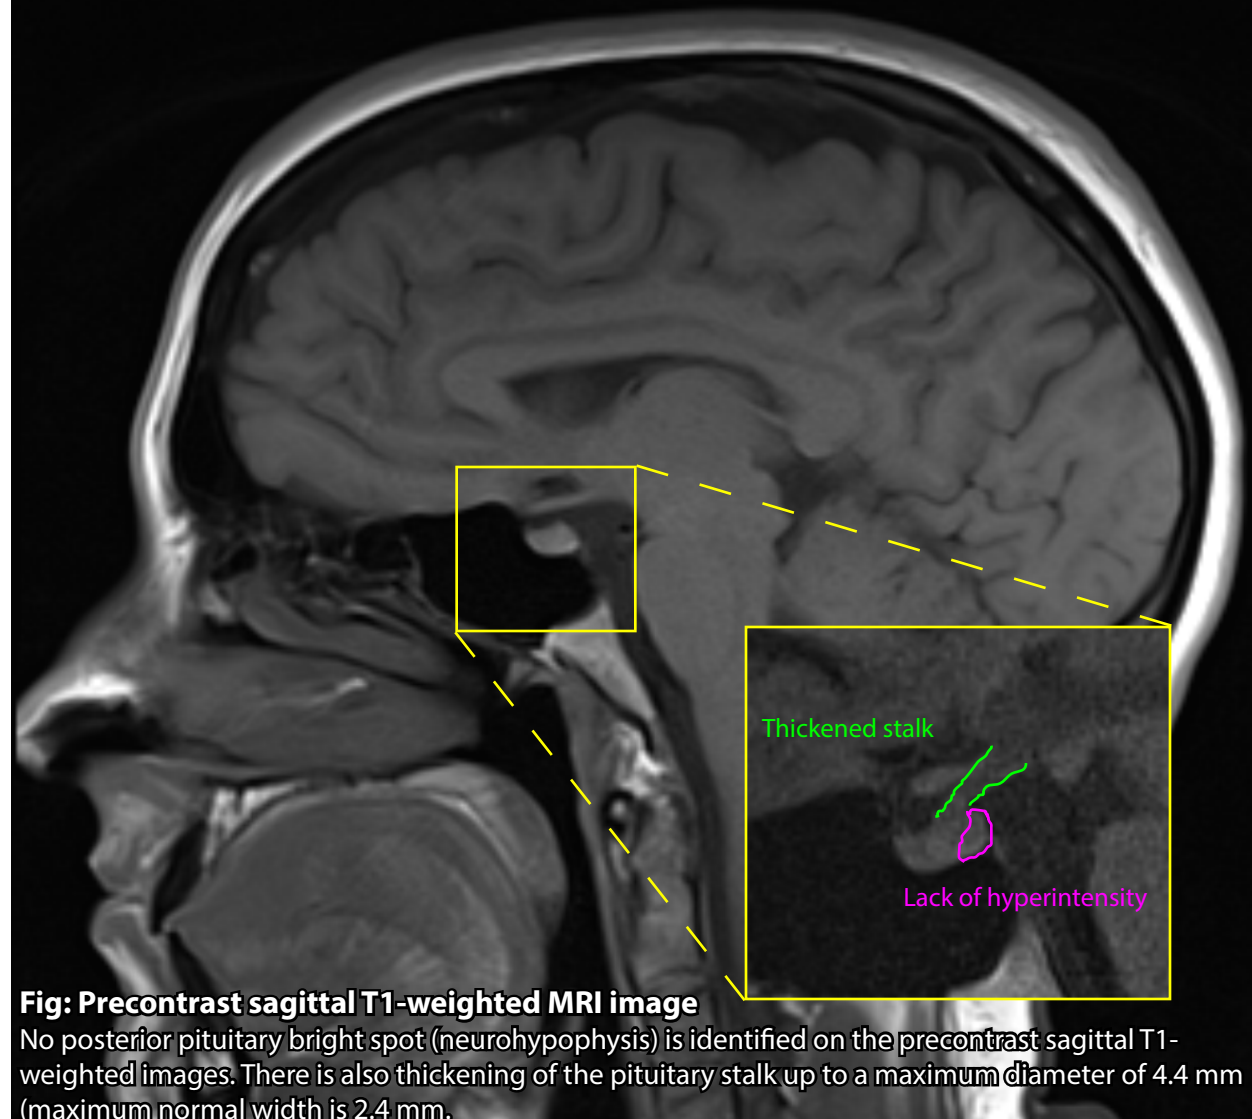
Precontrast sagittal T1-weighted MRI image
